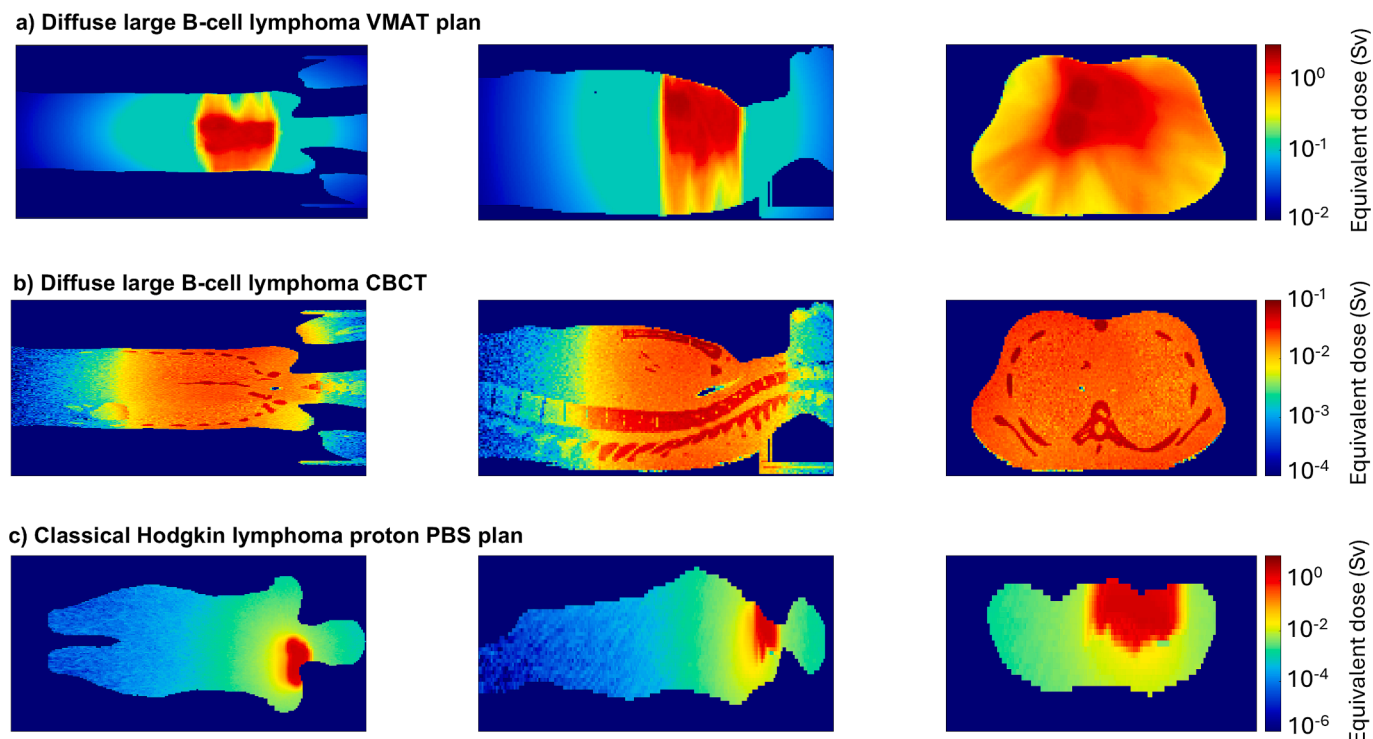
Dose distribution in the diffuse large B-cell lymphoma (DLBCL) a) VMAT fraction, b) DLBCL CBCT fraction, and c) classical Hodgkin lymphoma proton PBS fraction (c). From left to right: coronal, sagittal and axial views at the isocenter plains.
